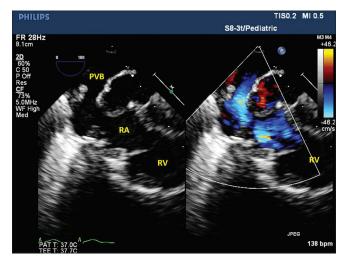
The transesophageal echocardiographic image was taken at the mid-esophageal level, 0°, probe rotated towards right side with color compare after surgical correction of pulmonary venous baffle (PVB) stenosis showing a laminar flow in the PVB. RA: Right atrium; RV: Right ventricle
